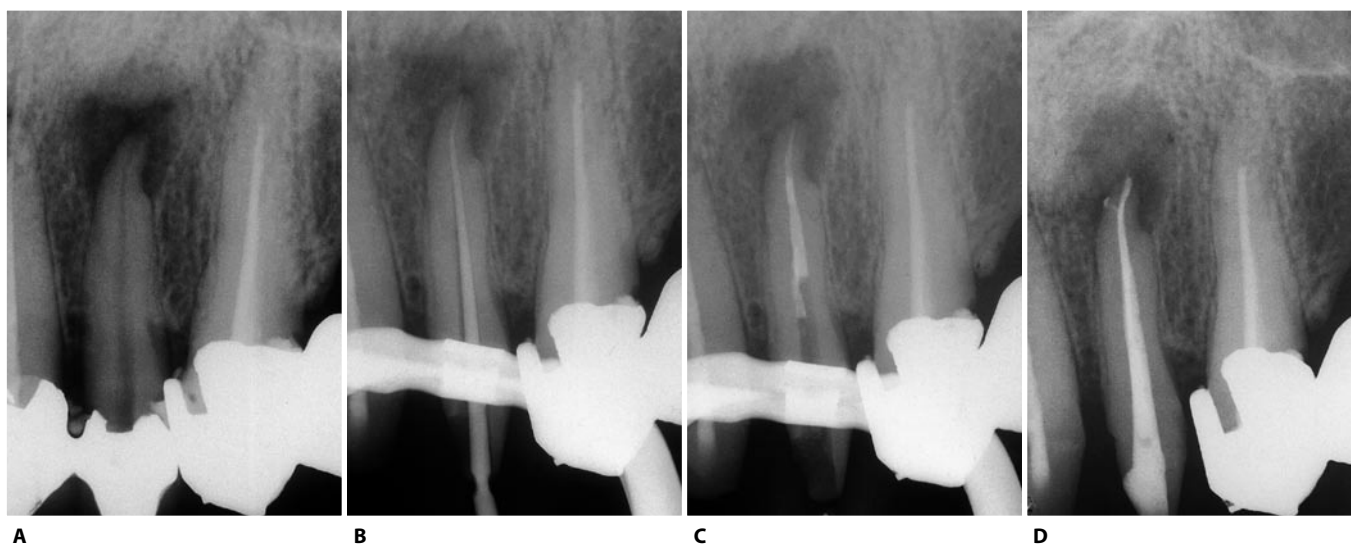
A. Preoperative radiograph of an upper left lateral incisor. B. Intraoperative radiograph of the cone fit. C. Radiograph of the apical compaction: the gutta-percha appears to be compacted for about 4 mm, then seems to fold. In the most apical portion, it has not been modified in the least. It is necessary to advance more apically with the heat-carrier and compact better. D. Postoperative radiograph: the obturation material now seems homogeneous and well compacted. A lateral canal has also been filled.
